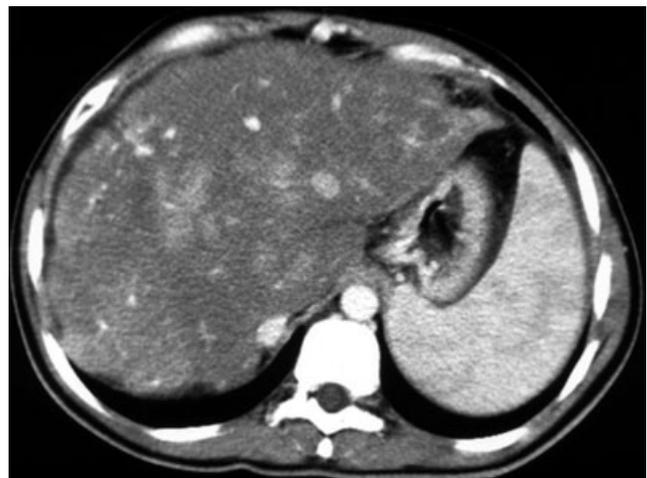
Computed tomography scan of the abdomen showing hepatosplenomegaly. The liver is heterogeneous with an irregular contour. The hepatic vein could not be visualized.
